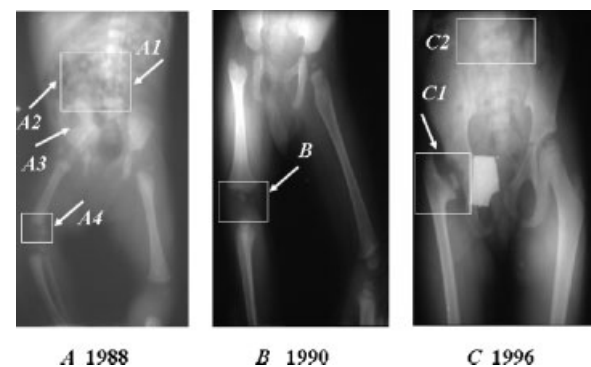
The X-rays present the progression of the Conradi-Hunermann syndrome (CDPX2) disease. A: Five-month-old female child was diagnosed with the disease. Changes are observed in the spine (A1), ribs (A2), proximal (A3), and distal (A4) femoral epiphyses, leading to a short femur and leg length discrepancy (B). Ossification of the femoral head and distal femur continued at a very slow rate (C1) and the changes in the spine (C2) led to scoliosis at 8-years-old.
